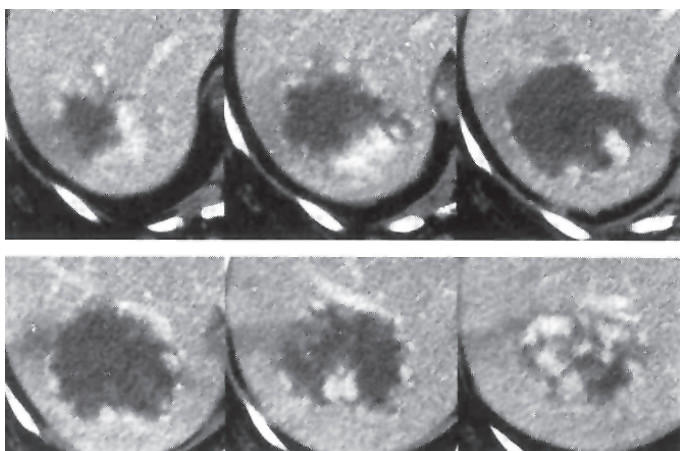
Contrast Enhanced CT: Haemangioma, hypodense lesion filling with contrast from the periphery on delayed views
